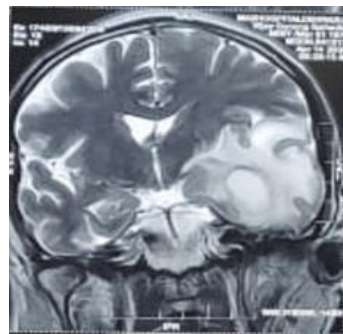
MRI Brain Coronal section T2 hyperintense lesions with t2 hypointense rim in left temporal lobe and left cerebellum and vermis With disproportionate surrounding edema, Mass effect seen in the form of effacement of adjacent sulcal spaces, cerebellar folia, Left lateral and 4th ventricles
